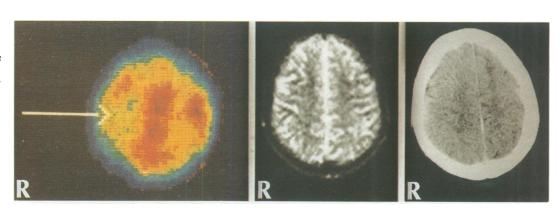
The same imaging sequences are shown from a severely disabled 19 year old with a left hemineglect syndrome three months after trauma. The right parietal abnormality is shown only by SPECT.
